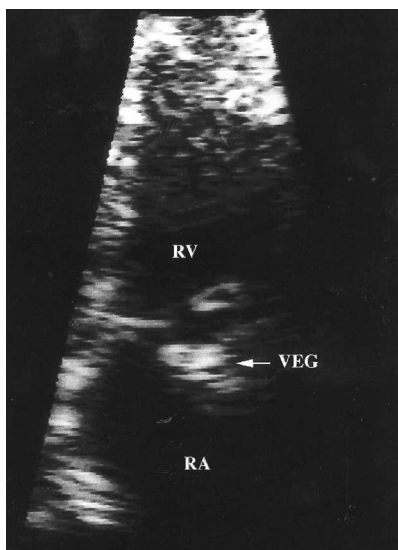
Transthoracic echocardiogram showing vegetation (VEG) adherent to tricuspid valve. RA = right atrium; RV = right ventricle.
